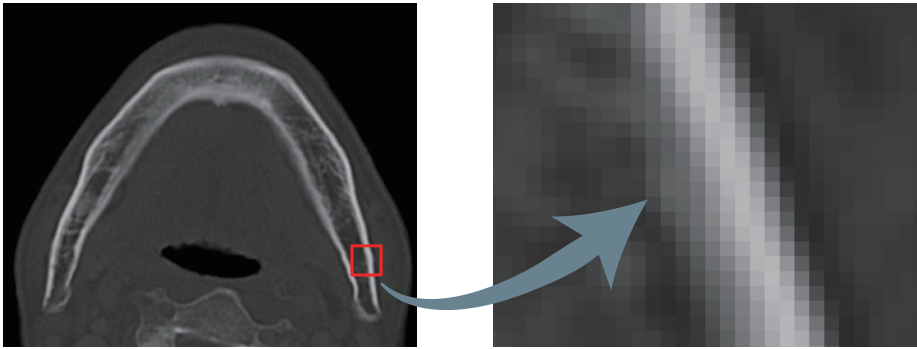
Enlarged CT image (mandibular bone).
